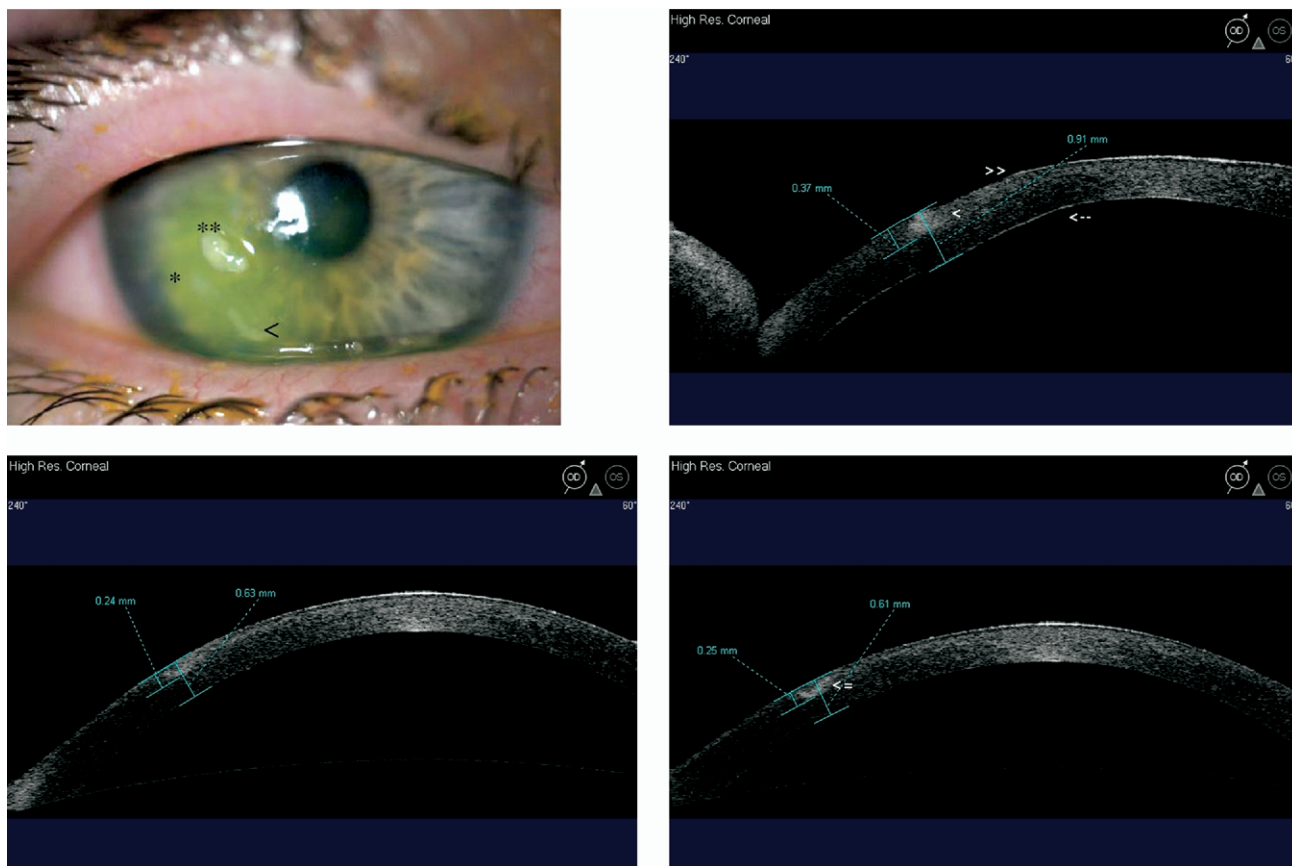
Images demonstrating microbial keratitis in a patient with recurrent corneal erosion syndrome, including serial high-resolution AS OCT images at the 60-degree meridian. (Top left) Anterior segment photograph obtained at presentation showing corneal infiltrates (* and <) and mucus (). (Top right) AS OCT images obtained at presentation through the lower infiltrate (<) showing corneal infiltration (<) and loss of epithelial continuity (>>). The lower border of the epithelial defect cannot be seen because of the underlying hyperreflective stromal infiltration. Stromal edema has resulted in a change in convexity of the posterior corneal surface (arrow). (Bottom left) AS OCT image obtained 10 days after initiation of treatment showing reduction of infiltrate and CT; an intact epithelial surface is now present. (Bottom right) AS OCT image obtained 17 days after initiation of treatment showing further reduction of CT and the development of scar tissue (arrow).
